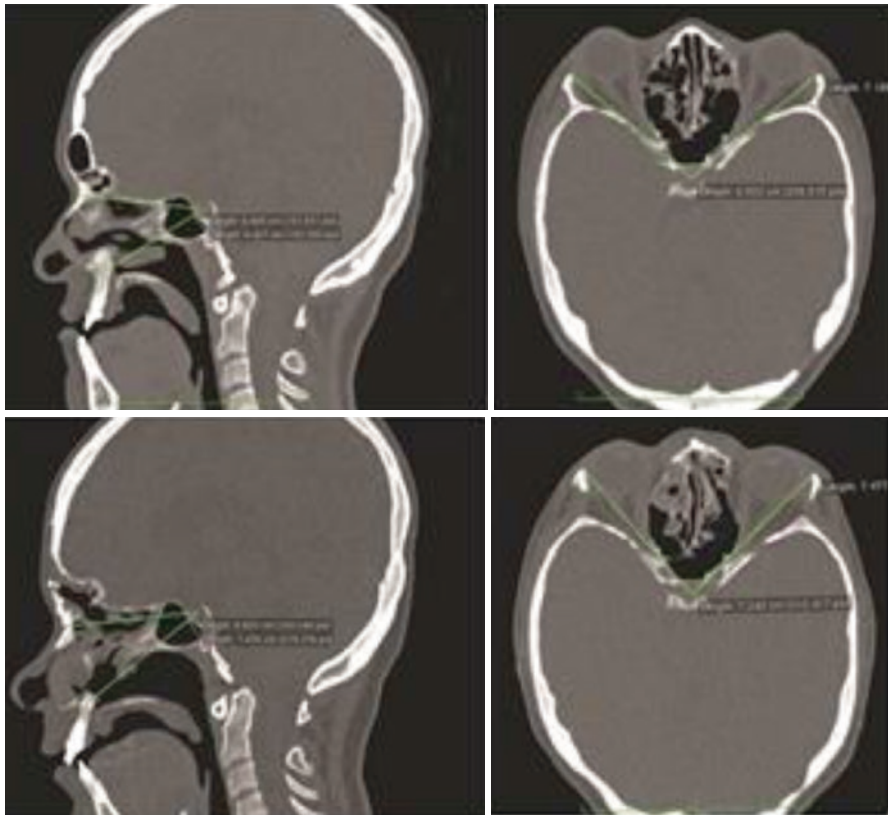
Pre- and postoperative CT measurements were taken using OsiriX software of sella-nasion and sella-A point and compared with measurements between sella and the lateral orbital wall
